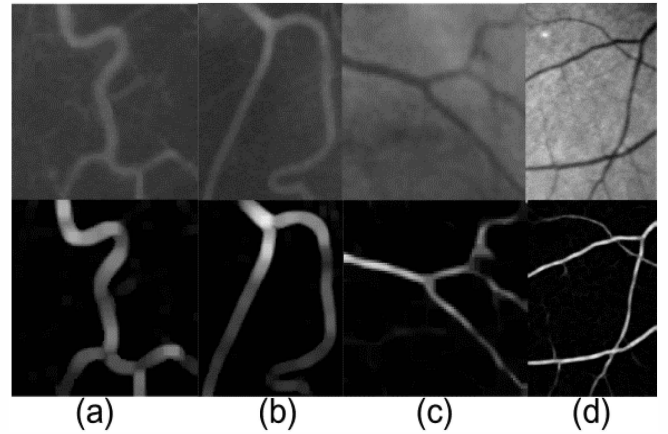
Performance of our method on degenerated clinical images. The top row shows various modal clinical images for evaluation, the middle row shows the performance of our method, and the bottom row demonstrates the initial curves by using our method. (a) DSA, (b) and (c) CTA, (d) retinal vessel image.
